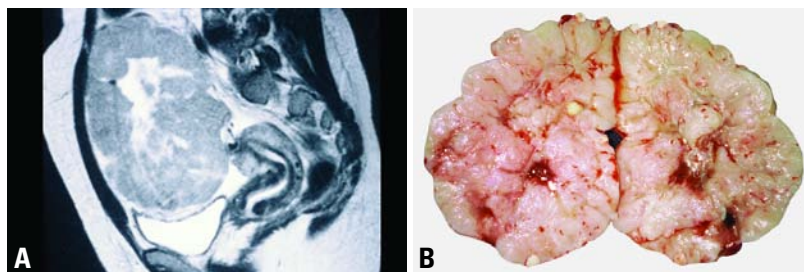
Dysgerminoma in a 28 year old nulligravida woman. A Magnetic resonance image sagittal view shows a 10 x 15 cm predominantly solid tumour with some central cystic changes. B Sectioned surface of the tumour shows a predominantly solid, multilobulated appearance with some cystic degeneration and foci of necrosis.
